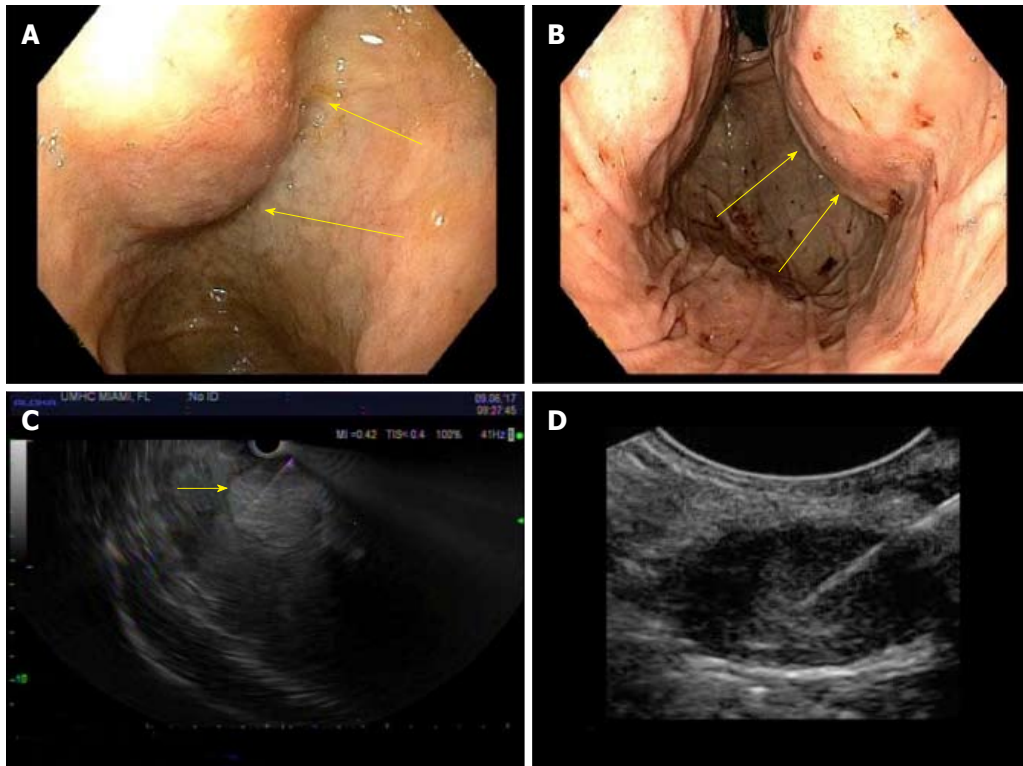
Endoscopic ultrasonography (EUS) diagnosis of primary liver tumors. A and B: Indentations seen in the duodenal bulb and stomach, from large lesions in the right and left lobes of the liver; C: On EUS, the entire liver tissue was seen replaced by numerous hyperechoic lesions of medium size, causing hepatomegaly and hence indentations. Fine needle aspiration (FNA) of a prominent and accessible hyperechoic lesion obtained, which was diagnostic of neuroendocrine tumor; D: In another patient, EUS-FNA of solitary hypoechoic liver lesion obtained, which diagnosed hepatocellular carcinoma.
